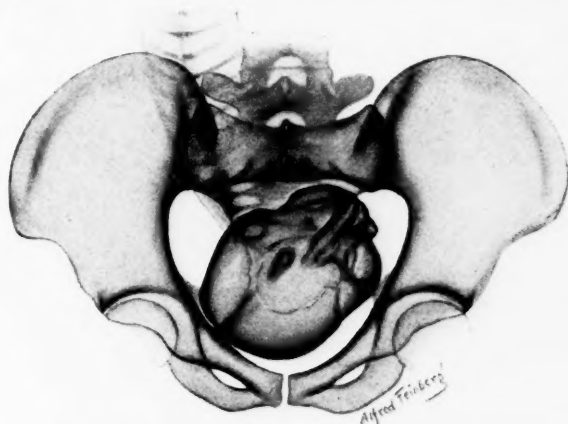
First x-ray examination in labor. Head descending through soft part axis situated in the fore-pelvis. Head position R. O. T. Type of pelvis typical android.
